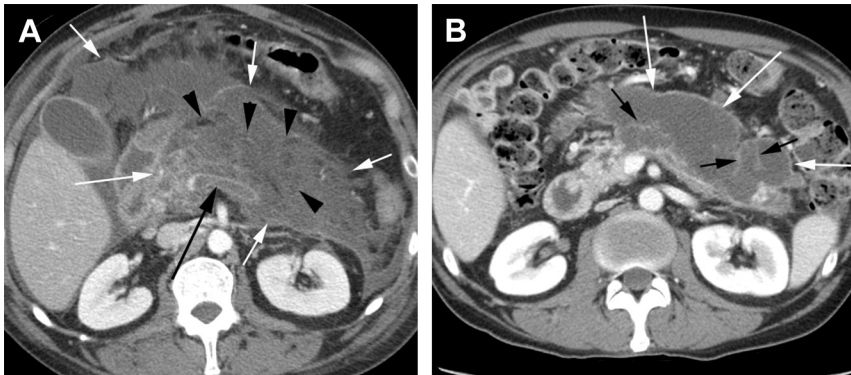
Acute necrotizing pancreatitis: peripancreatic and parenchymal necrosis, 8 days after onset of symptoms. (A) An axial CT image in a 44-year-old woman with heavy EtOH abuse demonstrates necrosis of the pancreatic parenchyma with only the head of the pancreas partially enhancing (*long white arrow*) and extensive ANCs (*short white arrows*) containing areas of fat necrosis and heterogeneity (*black arrowheads*). Also note the splenic vein thrombosis (*long black arrow*). (B) Same patient as Fig. 8A 5 weeks later. The ANCs have matured into WONs involving the pancreas and peripancreatic areas with an enhancing capsule (*white arrows*) clearly demonstrated. Also, multiple loculations (*black arrows*) are seen.
